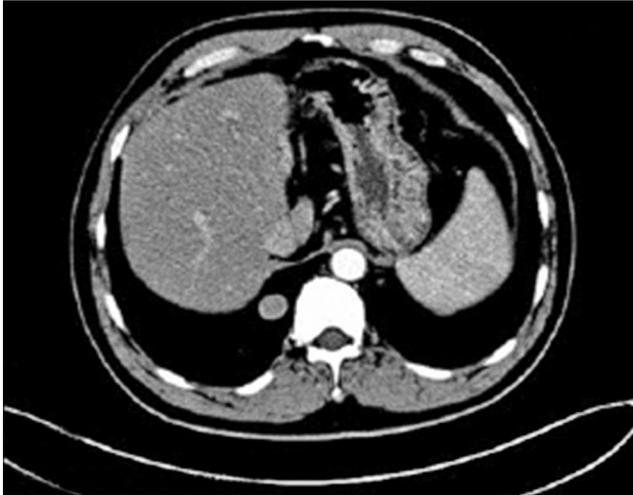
Preoperative thoracic computed tomograph showing high-density regular mass in the right lower lung.
